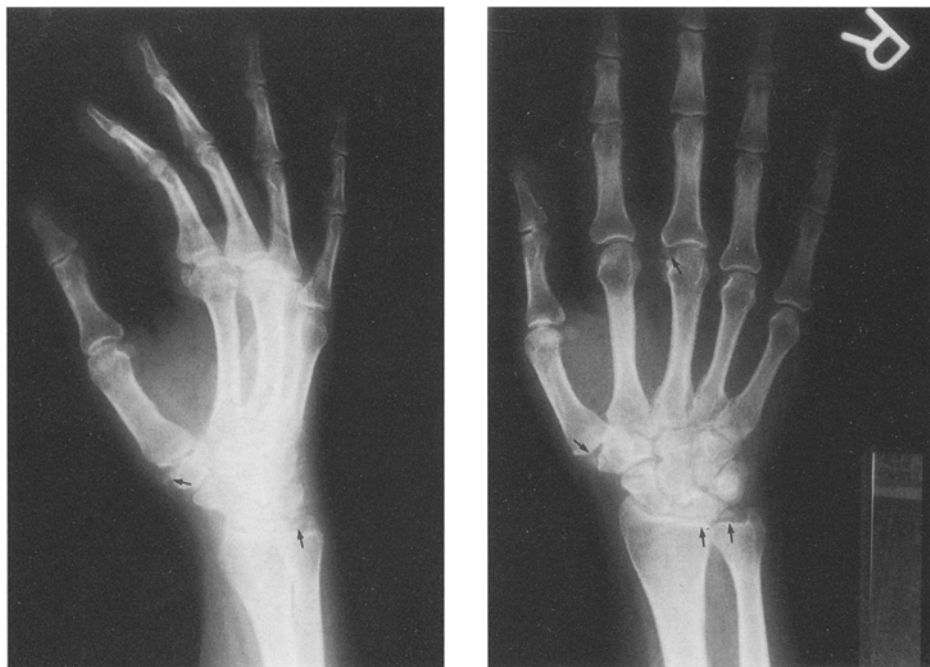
Recent radiographs of both hands showing denser chondrocalcinosis of the triangular fibrocartilage of the wrist, third metacarpophalangeal and first carpometacarpal joints (arrows) and a narrowed radiocarpal joint space (compared with radiograph in Fig. 2, which was done at 26 years of age).
